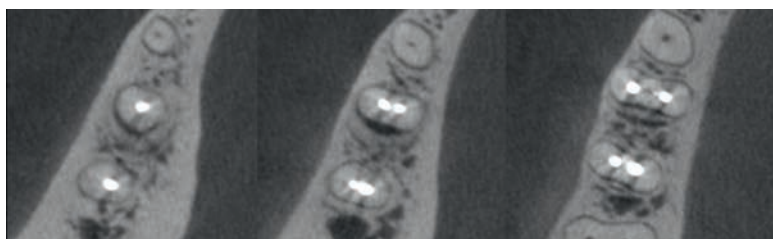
CBCT axial images (5-month follow-up).
